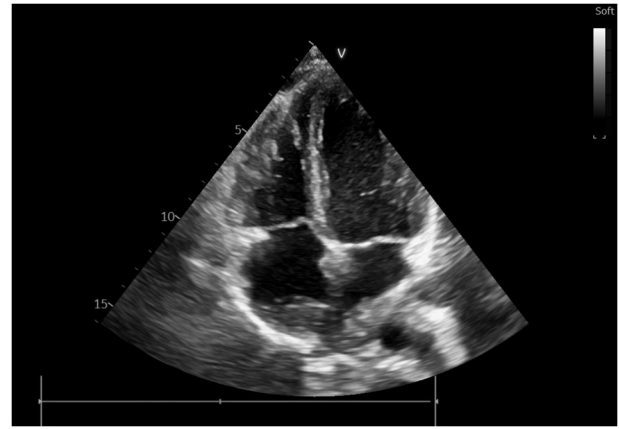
Echocardiography at 1 week after the initial evaluation (apical four chamber view) revealing that the atrial mass exhibits an increase in size, infiltrating the roof of the right atrium, interatrial septum, left atrium and the right upper pulmonary vein.
